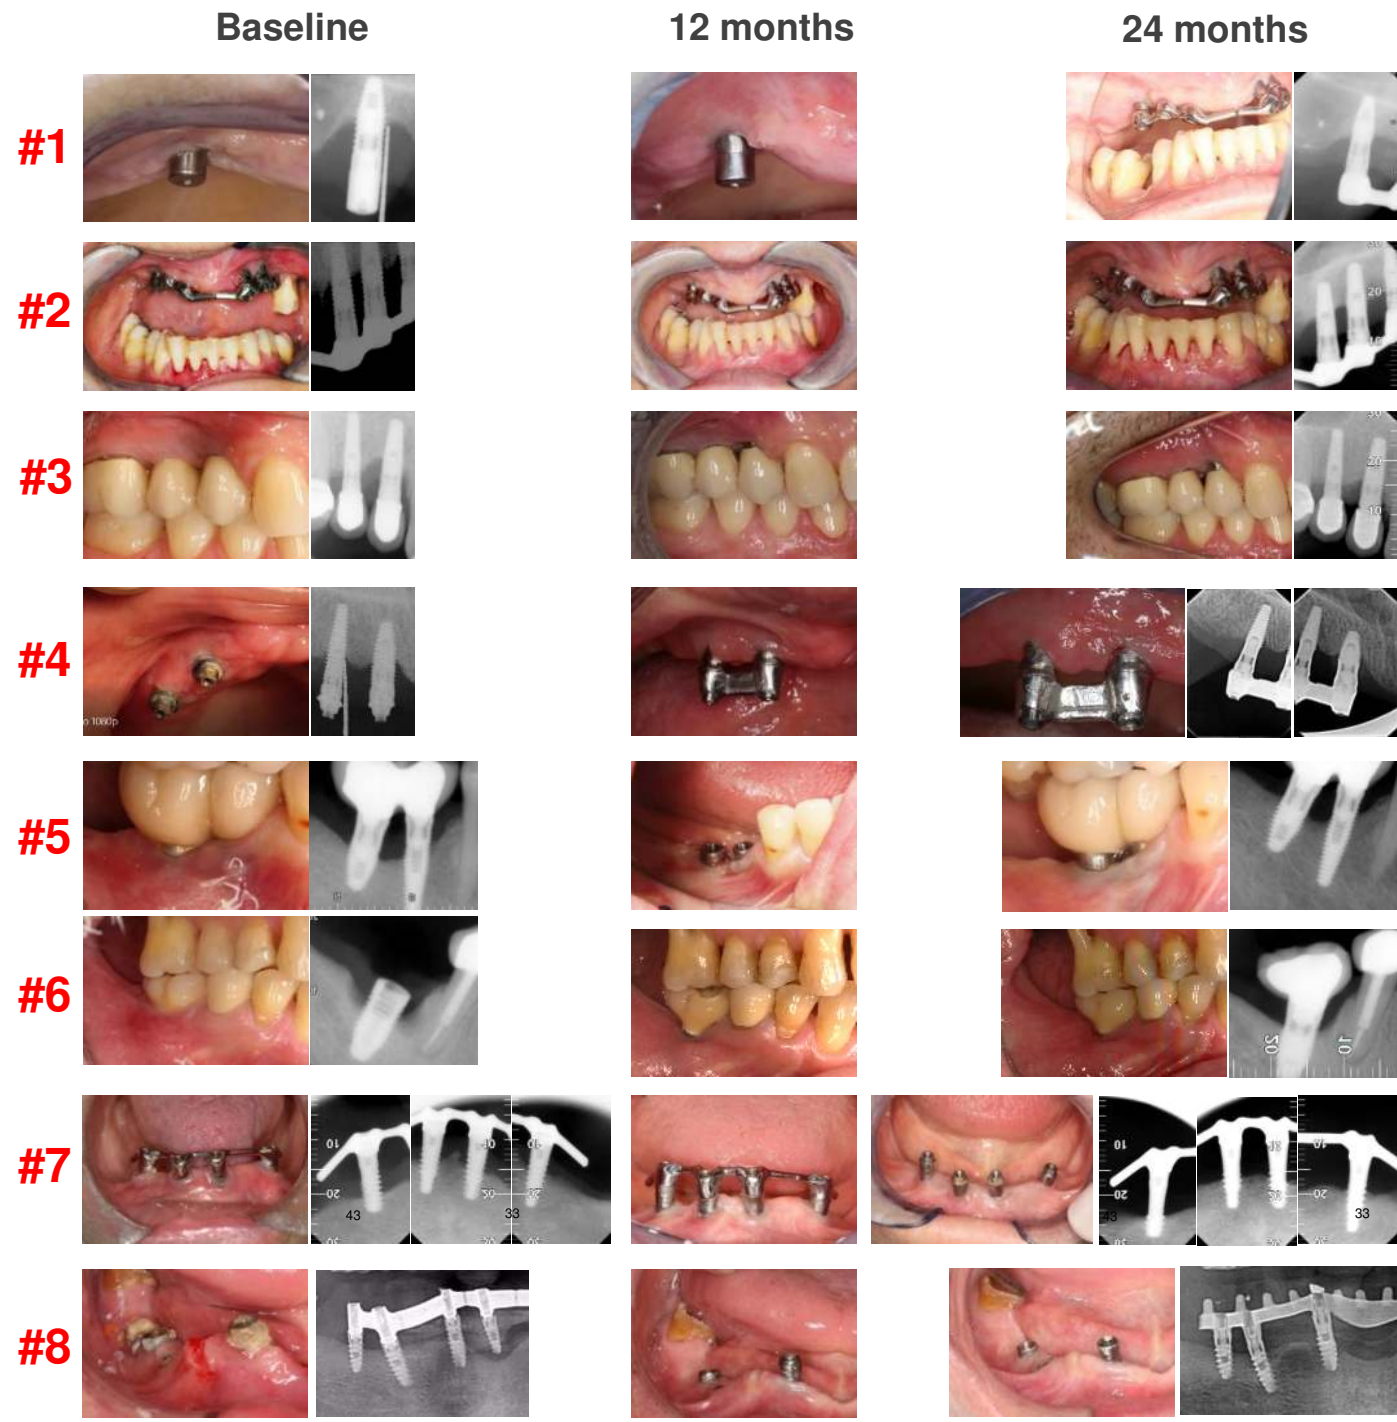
clinical and radiographic images regarding clinical cases at baseline, 12 and 24 months after implantoplasty.
